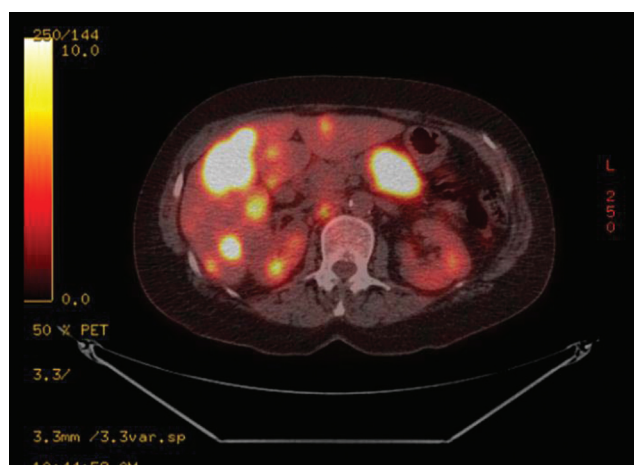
PET scan demonstrating a mass in the tail of the pancreas, measuring 3.8×6.1 cm, with an SUV of 17.4.
